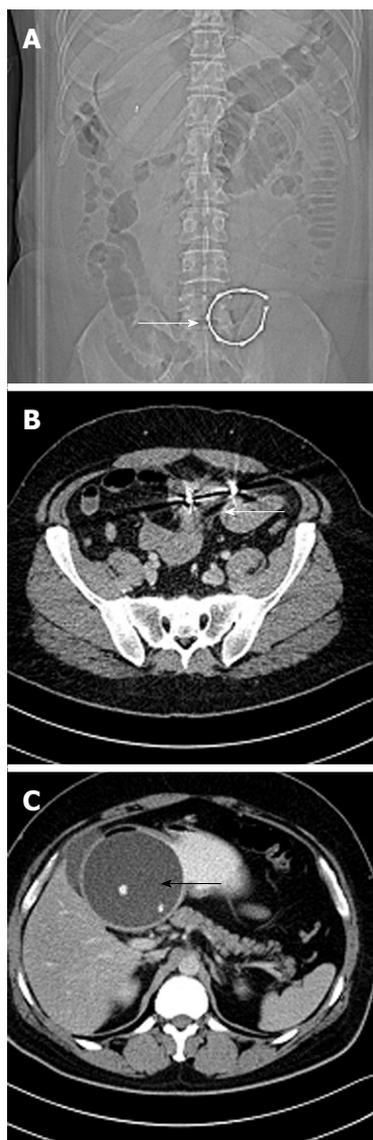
Abdominal computed tomography scan showing the safety ring migrated to the small bowel (A and B) (white arrows) and (C) the balloon was in the stomach (black arrow).
